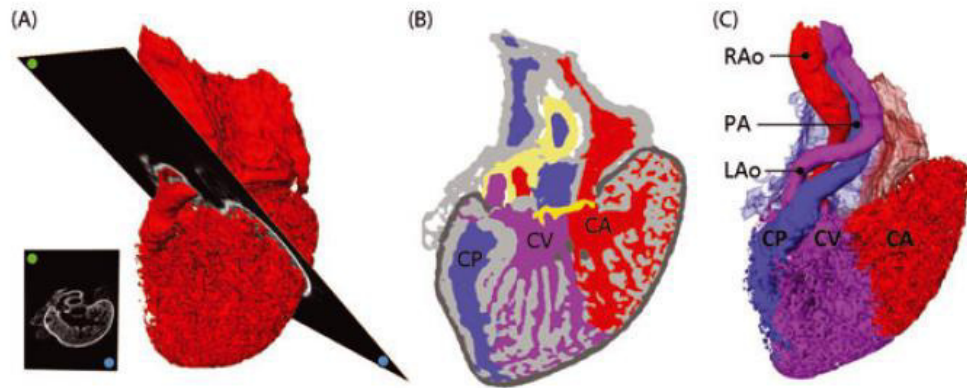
Volume rendering from nuclear magnetic resonance imaging of a heart of *Eunectes notaeus*.
